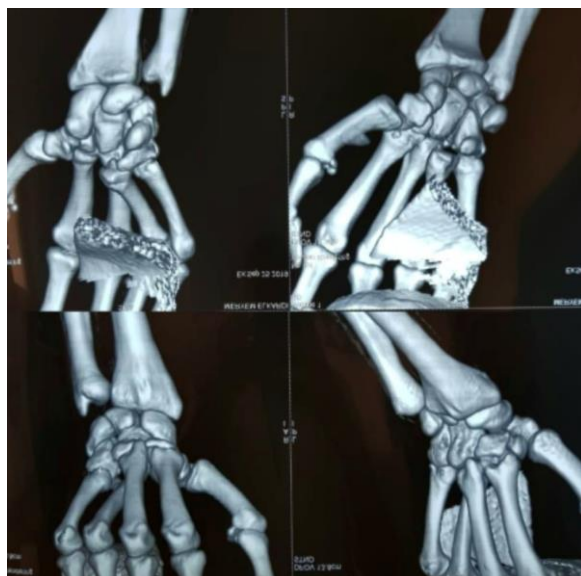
CT scan of the hand showing a pure palmar dislocation of the 4th metacarpal.
